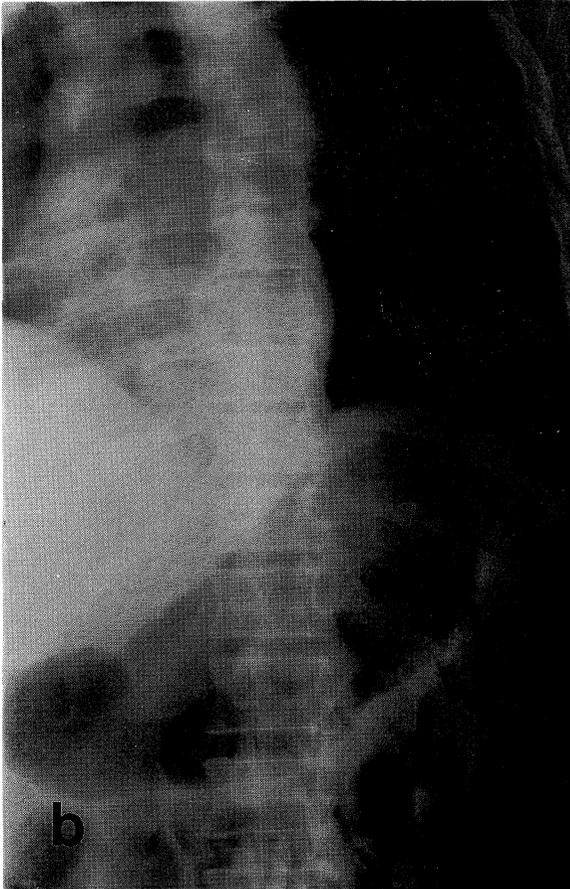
Bone radiography of the thoracic vertebrae: Faint osteolytic change can be detected.
